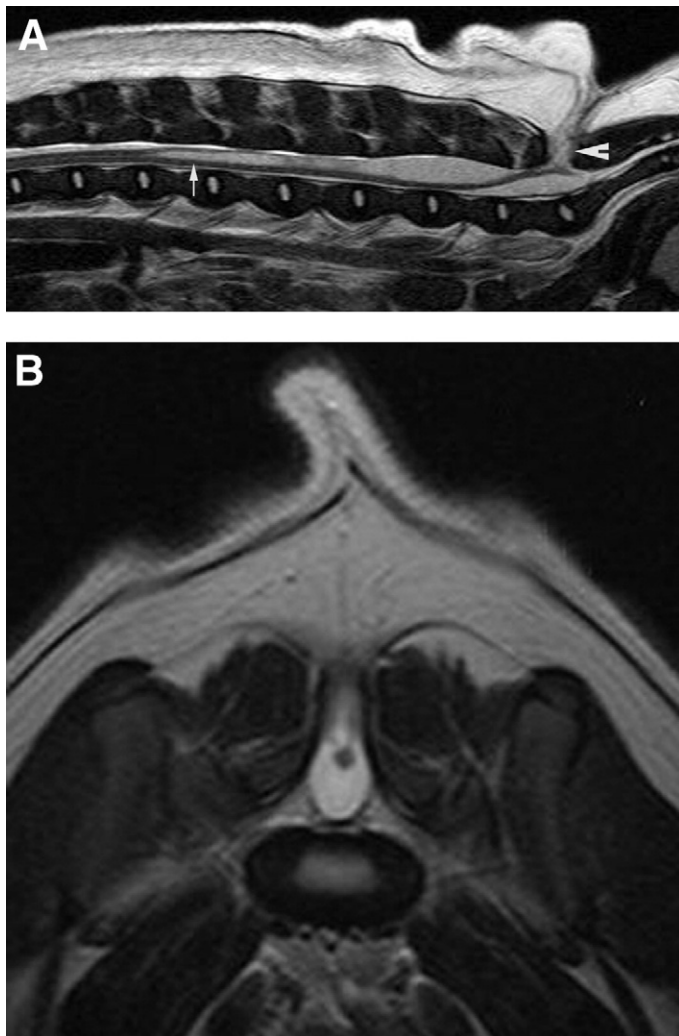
Magnetic resonance image. (A) Sagittal T2-weighted image. Syringohydromyelia (arrow) is apparent starting at the cranial aspect of L2. The meningocele (arrowhead) extends dorsally through the vertebral column. (B) Transverse T2-weighted image at the level L7-S1. Image courtesy of Sharon Gottfried, VMD, DACVS.
